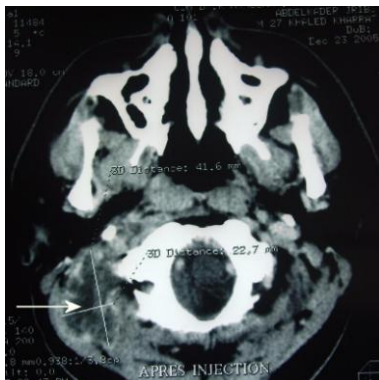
Axial contrast-enhanced CT: Large right-sided neck abscess, with peripheral and irregular enhancement
